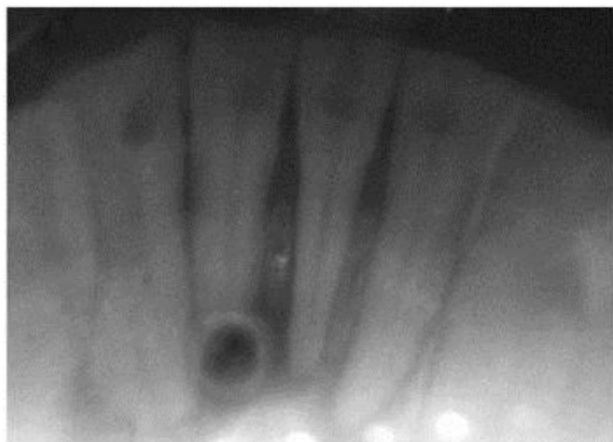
Radiographs shows a periapical cyst involving lower anteriors with respect to 31,32,41.
